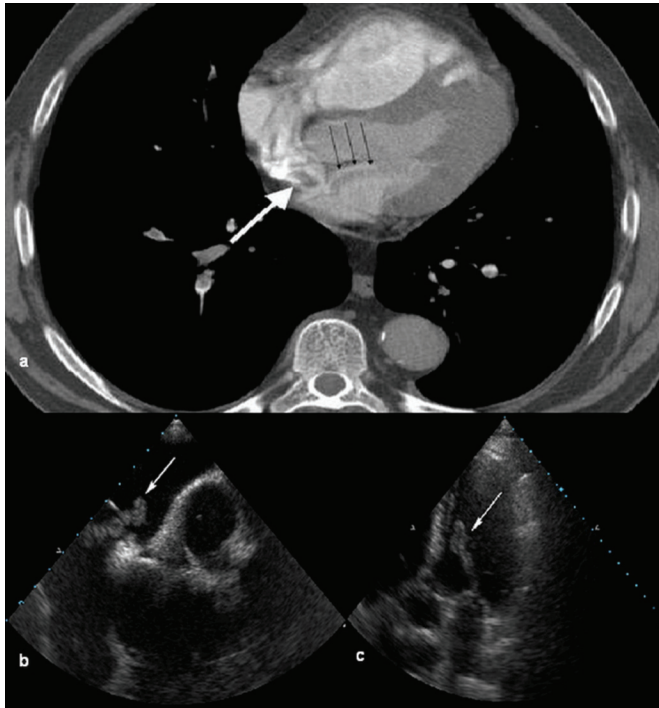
A, Computed tomography (CT) angiography showing emboli in the right and the left atrium (black and white arrows). B, Transesophageal echocardiogram showing an embolus entrapped in a patent foramen ovale (arrow). C, Transthoracic echocardiogram with embolus impingement into the left ventricle (arrow).
